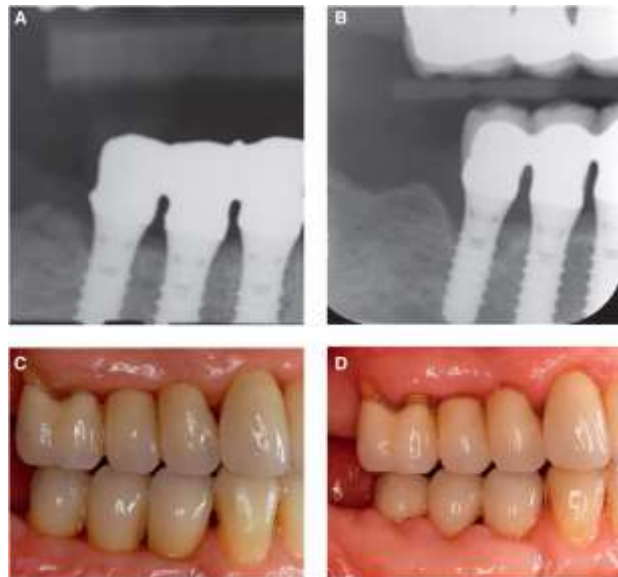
An example of the patient's radiographs taken at the time of prosthesis placement and taken again at the subsequent examination is shown in the images respectively.
